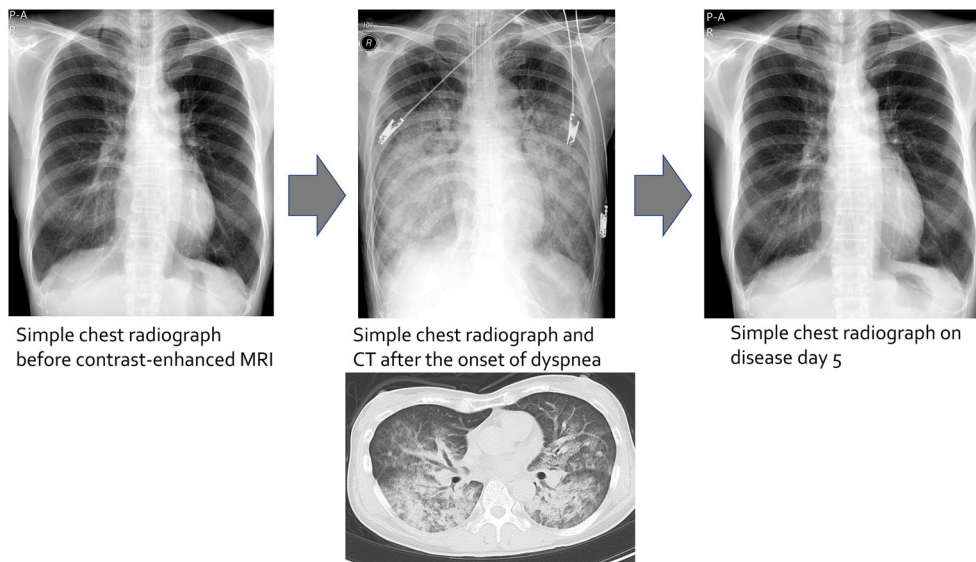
Simple chest radiograph obtained just before contrast-enhanced MRI. No abnormal findings in the lungs. Bilateral infiltrative shadows on a simple chest radiograph and CT after the onset of dyspnea. Simple chest radiograph on disease day 5. Improvement in infiltrative shadows was observed.
